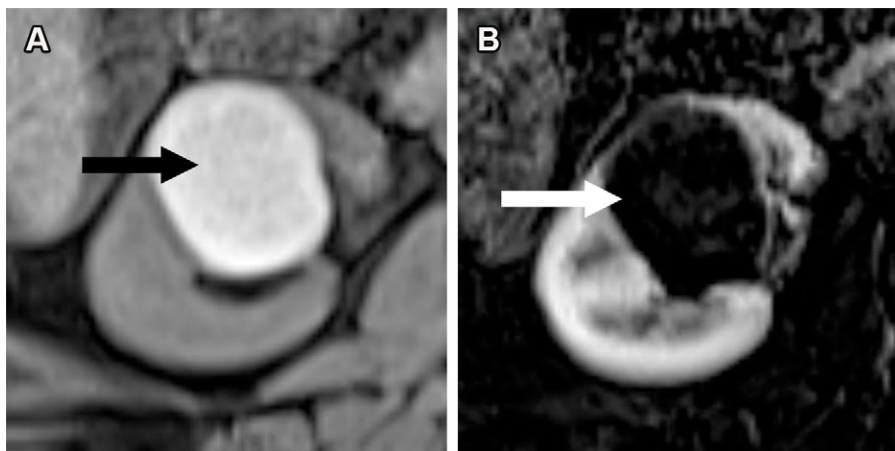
Hemorrhagic renal cyst in a 45-year-old woman with metastatic adenocarcinoma from an unknown primary site. (A) Axial precontrast T1-weighted MR image shows uniform T1 hyperintensity in a right renal mass (arrow). (B) Axial postcontrast CMP T1-weighted subtraction MR image shows no internal enhancement of the mass (arrow), consistent with a hemorrhagic cyst. Subtraction imaging is particularly helpful in assessing renal masses that exhibit intrinsic T1 hyperintensity to facilitate detection or exclusion of enhancement. The ccLS is not applied to hemorrhagic renal cysts.
